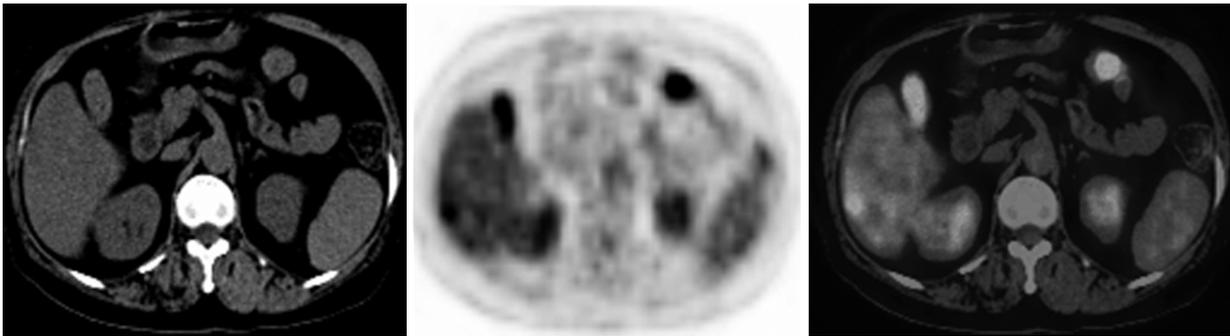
PET/CT imaging showing isolated hepatic metastasis in a 69-year-old female postoperative sigmoid carcinoma patient. CT scan did not find definite recurrence signs. PET imaging detected localized hepatic subcapsular hyper-intensive radioactivity. Local resection of liver lobe was performed in the reoperation, and metastatic adenocarcinoma was confirmed.
